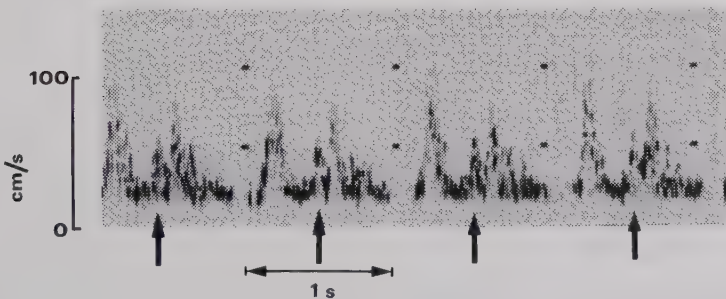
Spectral analysis of the Doppler signals from the fetal aortic blood flow (patient no. 1, 36th week of pregnancy). The beats are grouped in pairs; an additional spike (marked by an arrow) appeared in the second beat of each pair.
